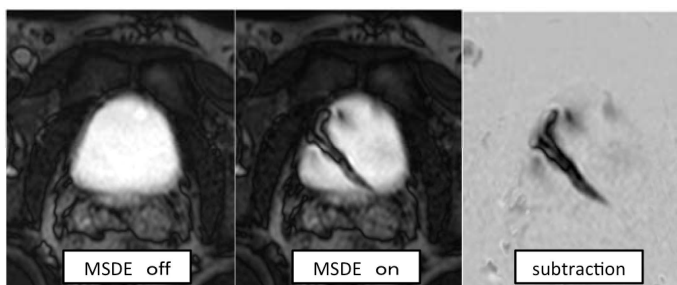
One frame of cine MR imaging in the urinary bladder. Flow jet phenomenon is clearly visualized with iMSDE.
